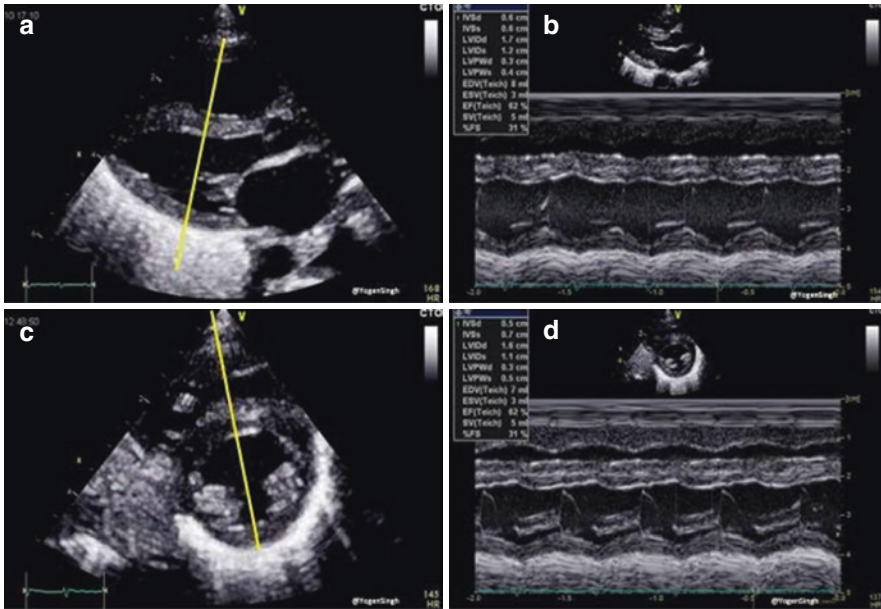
M-mode imaging on parasternal long axis and short axis views showing assessment of left ventricular systolic function. Images a and b show fraction shortening (FS) assessment on parasternal long axis view; images c and d show FS assessment in parasternal short axis view
